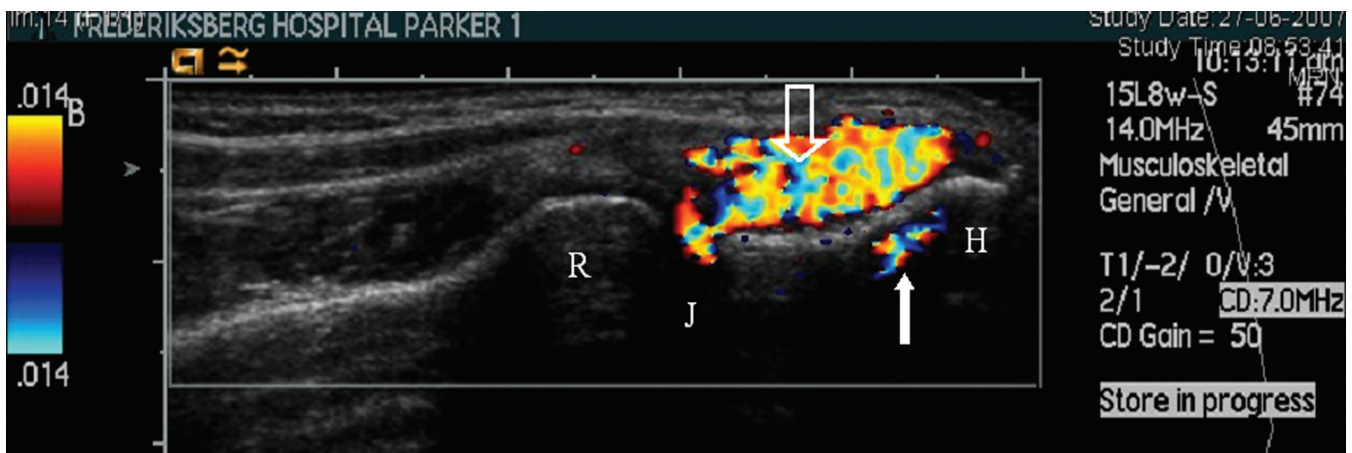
Mirror artefact in lateral epicondylitis. It is a longitudinal image of the elbow in a patient with lateral epicondylitis. H: humerus, R: radius; J: joint space. The hollow arrow points at the common extensor origin, which is filled with Doppler activity. The solid arrow points at Doppler activity below the bone surface. It is a mirror image of the Doppler activity in the common extensor origin. The mirror is the bone surface.
